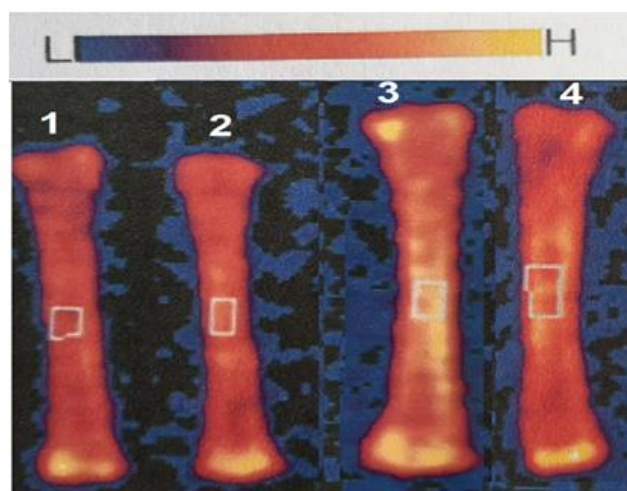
Radiographic image of the effect of different sources of zinc on tibia bone scans using dual energy X-ray absorptiometry at 35 days of age.
